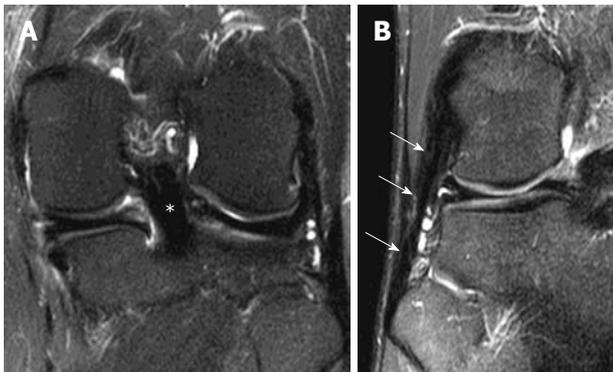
Coronal whole posterior cruciate ligament and lateral collateral ligament sign. Coronal T2-weighted fat suppression magnetic resonance knee images of two different patients with complete anterior cruciate ligament tear show that A: The entire posterior cruciate ligament (*); B: Entire lateral collateral ligament (white arrows) can be seen in a single coronal image.
